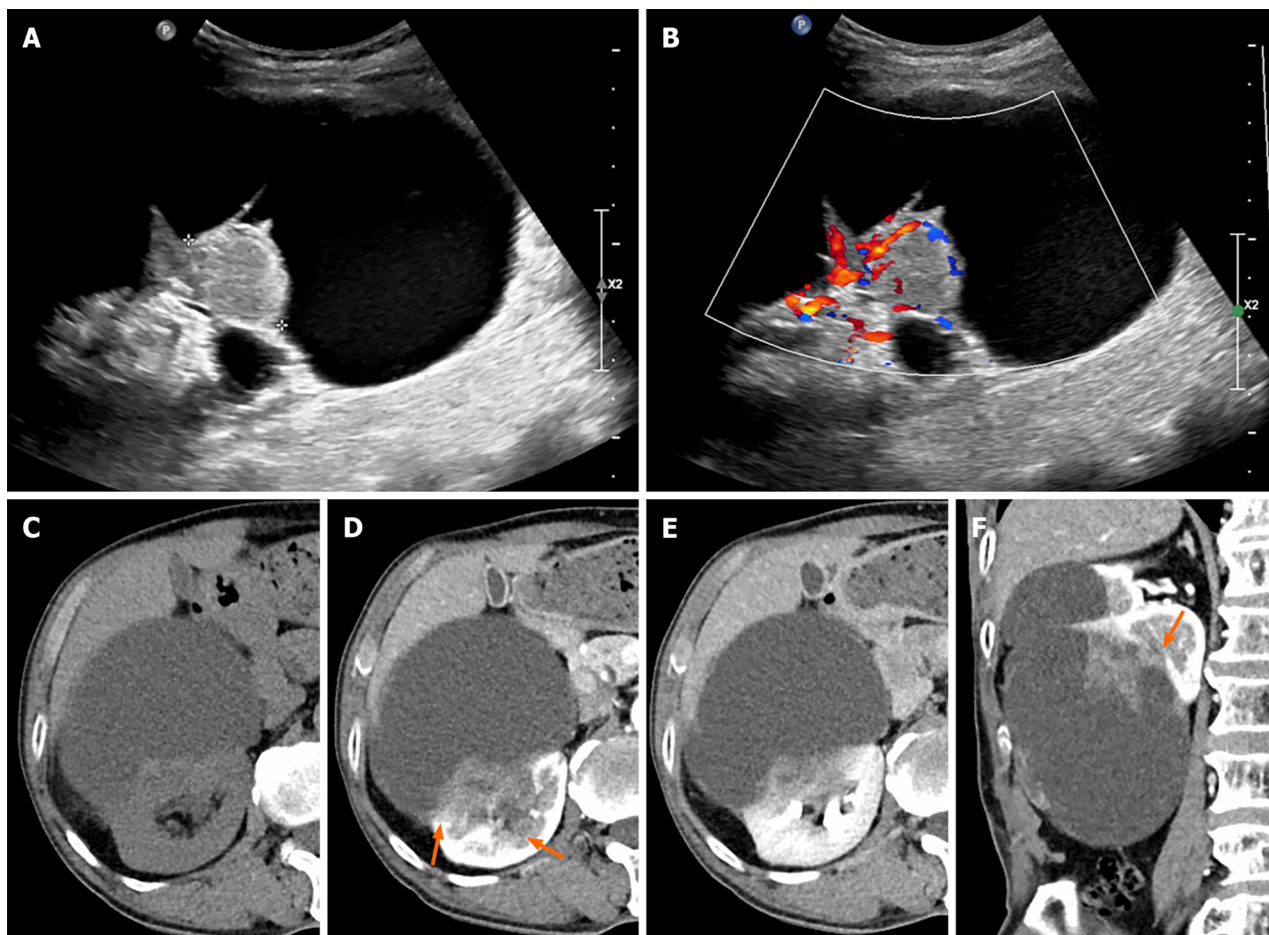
Initial ultrasound and abdominal computed tomography scan of the right kidney. A: An 11 cm × 10 cm cystic lesion is noted in the right kidney with a 3.2 cm solid component on ultrasound B-mode; B: Increased vascularity is seen in the solid component on color doppler mode; C: A pre-contrast phase axial computed tomography (CT) shows a cystic lesion with a mass at the posterior-lateral aspect of the right kidney interpolar region-lower pole. A subtle high-attenuation area is seen in the cystic lesion, suggesting hemorrhage; D and E: Corticomedullary and excretory phase axial CT shows progressive enhancement of the mass (pre-contrast phase: 40 HU, corticomedullary phase: 70 HU, excretory phase: 80 HU) and a suspiciously indistinct margin (orange arrows) and invasion of the sinus; F: Corticomedullary phase coronal CT scan shows an irregular enhancing mass in a lesion with indistinct margins (orange arrow).
